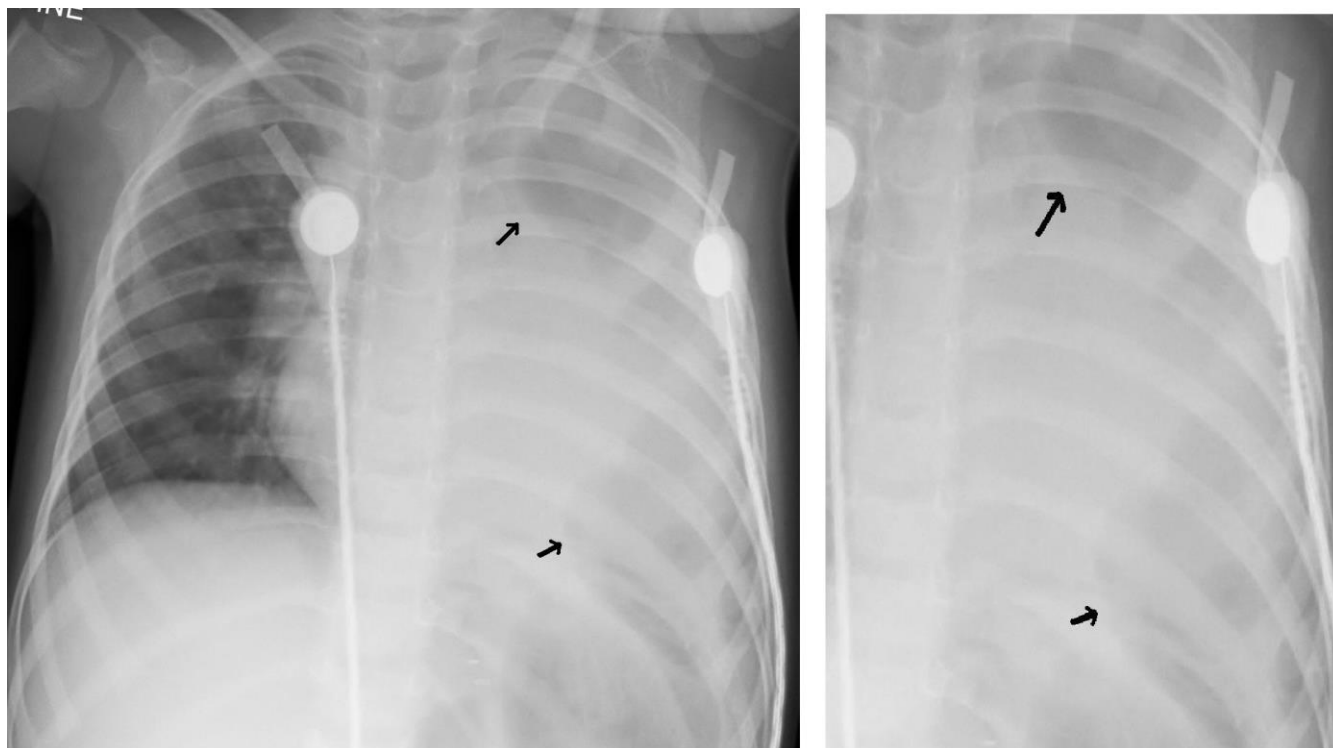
Supine, AP view of plain chest x-ray of a neonate showing congenital left sided diaphragmatic hernia. The black arrow points at the radiolucencies in the left side of the chest in continuity with the abdomen indicating bowel loops in the chest. The naso-gastric tube is also in the left hemithorax indicating that the stomach has also herniated into the chest. There is mediastinal shift to the right and the left costophrenic angle is obliterated. The x-ray also shows a well placed endotracheal tube, umbilical artery and umbilical venous catheters.
